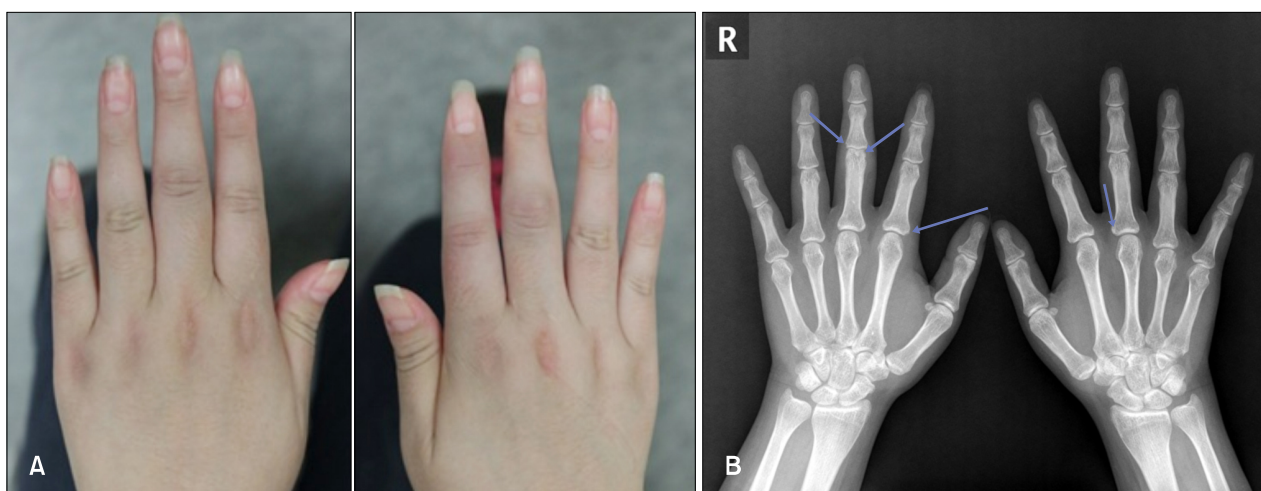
(A) Swollen proximal interphalangeal joints on bilateral third fingers. (B) Radiograph showing marginal erosion at the right third proximal interphalangeal joint, small bony proliferation at the right index metacarpophalangeal joint, and suspicious erosion at the left middle proximal interphalangeal joint.
